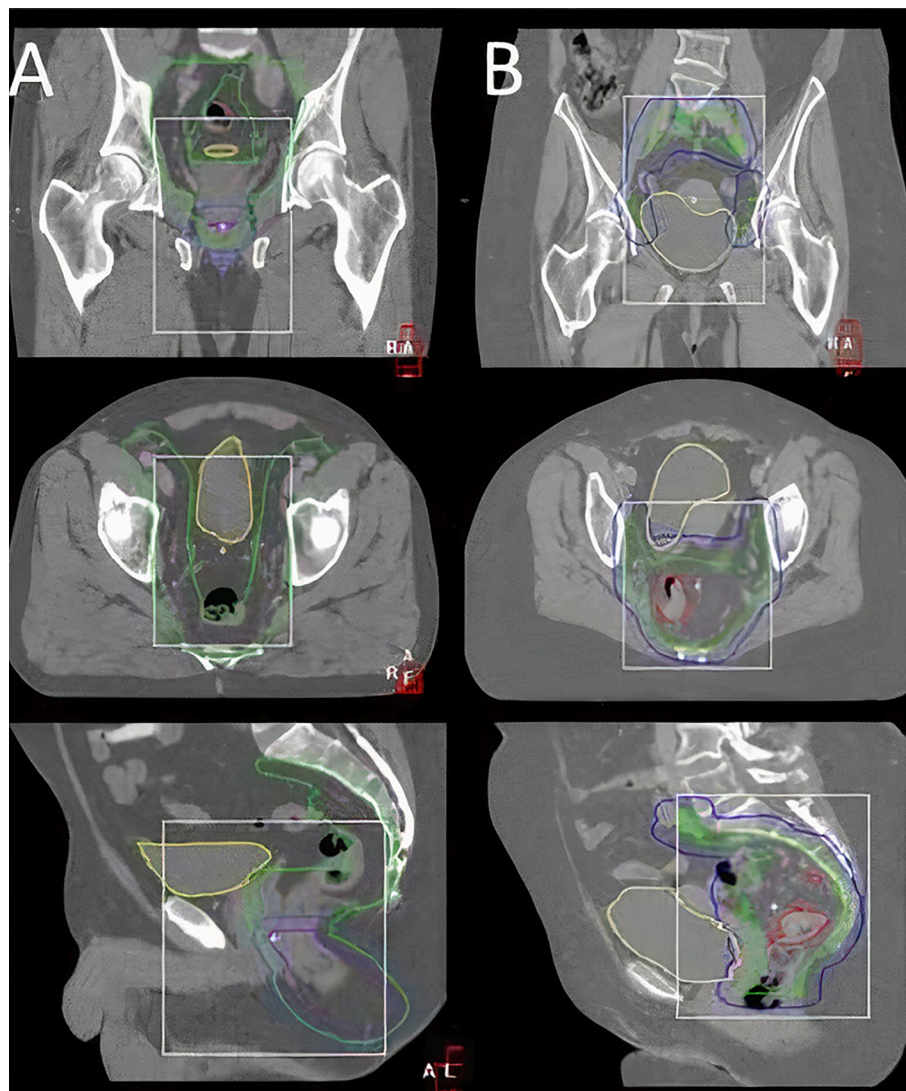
Example CBCT registration clip boxes for anal (A) and rectal (B) cancer sites respectively as positioned on a reference CT image.
